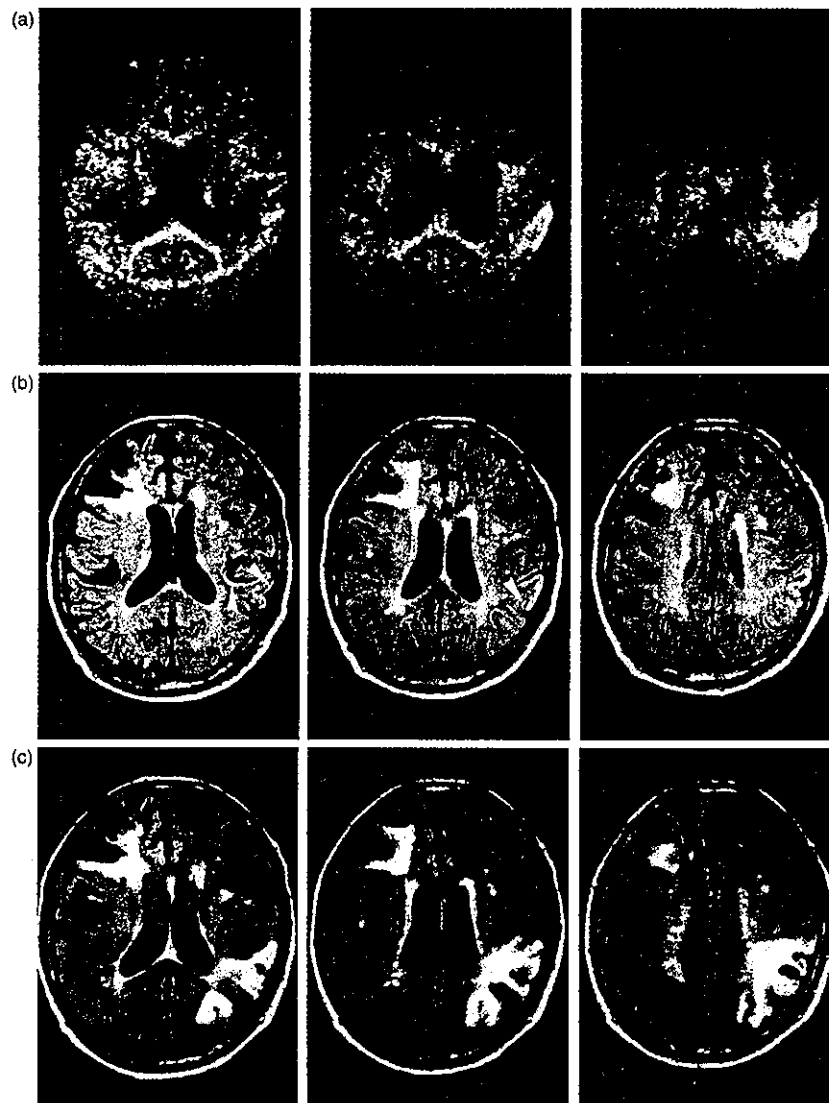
MRI studies in patient 1. DWIs taken at 3.5 hours after stroke onset demonstrates high intensity areas in the left angular artery region (a). FLAIR images show linear high intensities (arrowheads) in the region of the MCA branch (b). In FLAIR images 22 days post onset, the linear hyperintensity is not observed (c).
